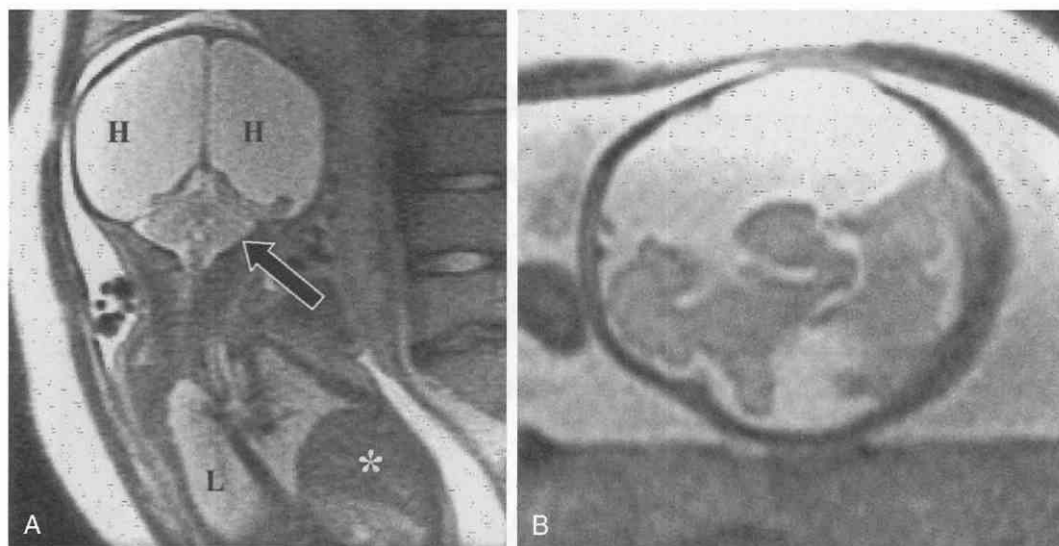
Single-shot, fast spin-echo imaging of a fetus to evaluate for severe hydrocephalus suspected on ultrasound. *A*, The image, in the sagittal plane relative to the mother but in the coronal plane relative to the fetus, demonstrates cerebrospinal fluid filling the right and left hemispheres (H). The cerebellum appears intact (arrow). The lungs (L) and liver (asterisk) are demonstrated. *B*, Preservation of some of the frontal lobe and temporal lobe on the right in a patchy distribution indicates hydranencephaly, not hydrocephalus. (From Outwater EK: Ultrafast MR imaging of the pelvis. *Eur J Radiol* 29:233–244, 1999.²⁵⁵)
